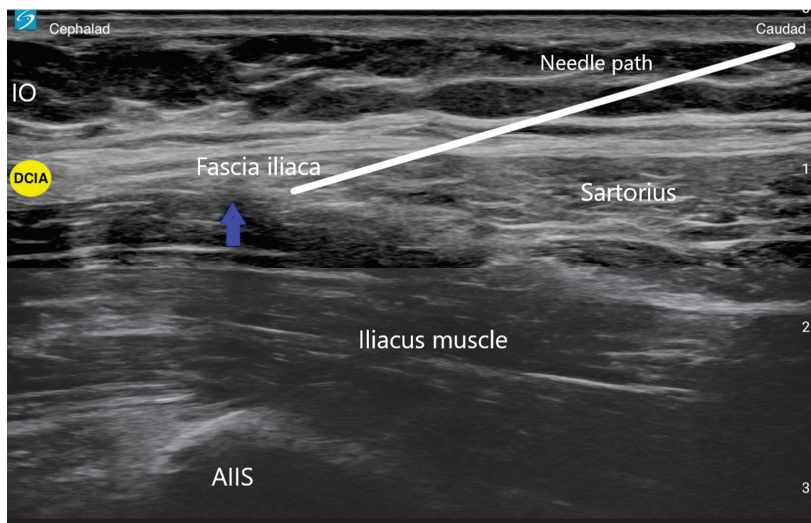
This is an ultrasound image of a supra-inguinal fascia iliaca (SIFI) block. The white line represents the direction of the needle. The blue arrow represents the location of local anesthetic injection. IO (internal oblique muscle); AIIS (anterior inferior iliac spine); DCIA (deep circumflex iliac artery).
